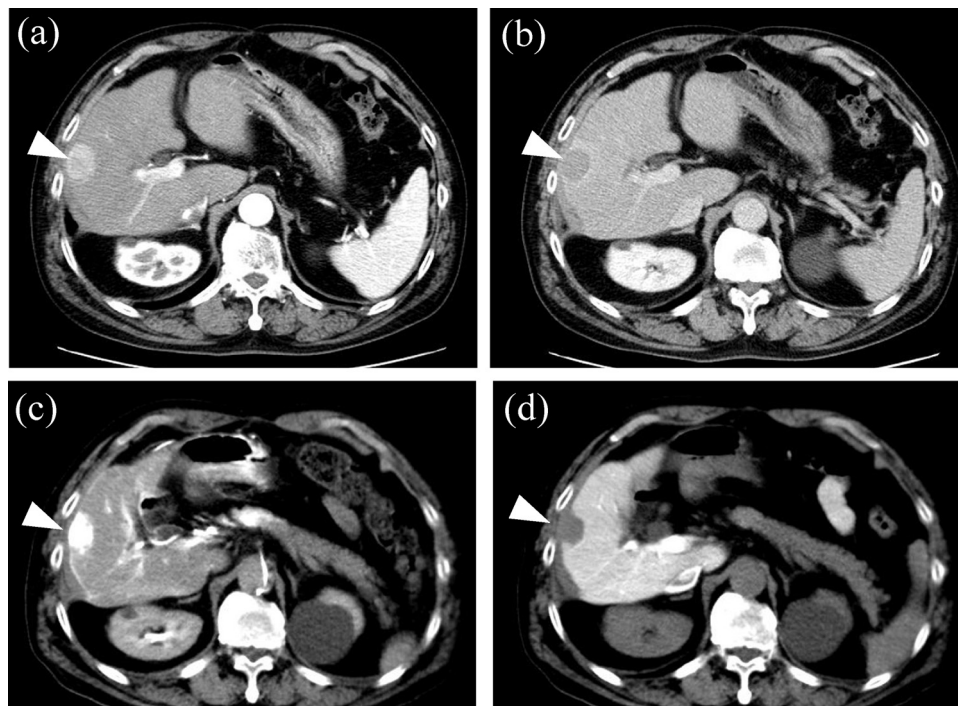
Abdominal dynamic computed tomographic (CT) image showing a 30-mm space-occupying lesion (arrowhead) in segment 5 of the liver, which was visible as a homogeneously enhanced lesion at an early phase (a), and was washed out at a late phase (b). CT during hepatic arteriography revealed a hypervascular tumor (c), and CT during arterial portography revealed a perfusion defect (d). No other tumors were found in the examination.
